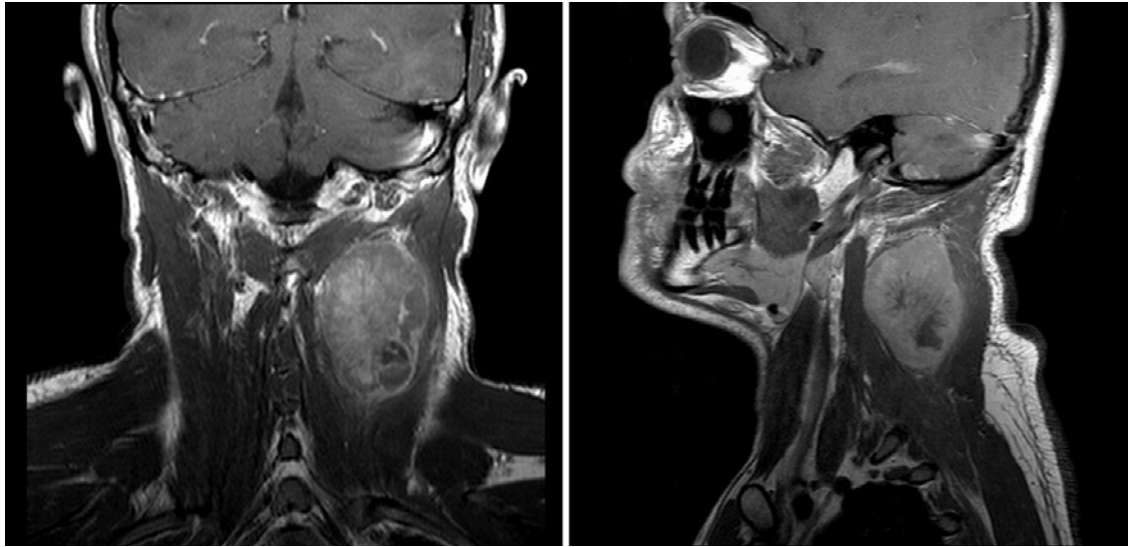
MRI: T1W-TSE-C Coronal and sagittal section, showing well isolated mass, no infiltration to peripheral tissues and close relationship with vertebrate.
